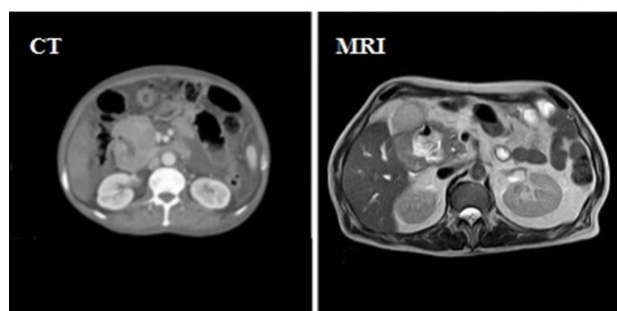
CT enhanced scan and MRI examination showing typical cases of primary duodenal adenocarcinoma.
